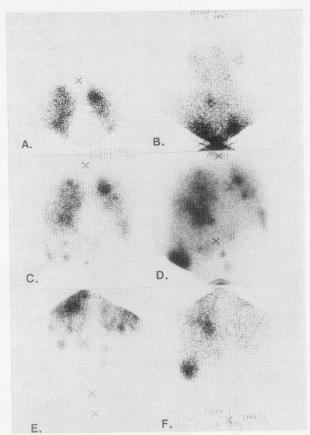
¹³¹I-MIBG scintigram. Left (A, C, E); the scintigrams were taken in 1983. Right (B, D, F); the scintigrams were taken in 1990. Abnormal accumulations are observed in the lung and the liver. In 1990, new abnormal uptake lesions of thyroid was noticed. The size of tumor in liver increased, that correlated the tumor by the CT scan.
